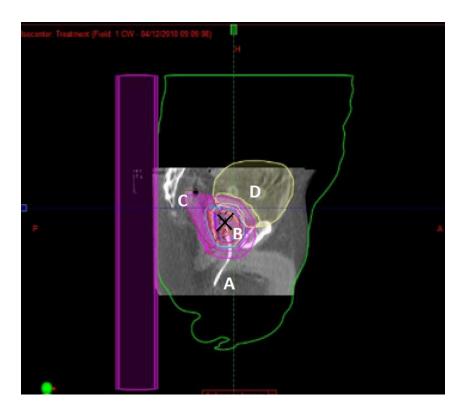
Sagittal SBRT CBCT. A – The transmitter cable, B – the high dose volume isodose distribution, C – the rectum, D – the bladder. The black X depicts the tip of the transmitter co-ordinates used for localisation, verification and real time motion management. The bladder, rectal volume, fiducial marker position and transmitter placement is assessed and compared to the original treatment planning CT scan.
